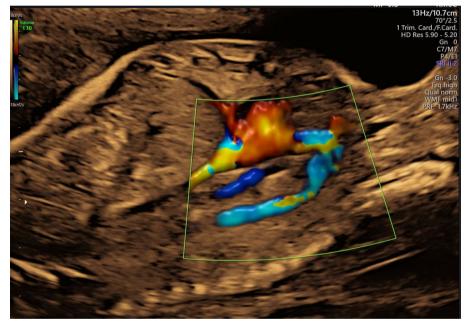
Abnormal vessel found during prenatal ultrasound screening at 24.2 weeks of gestation
